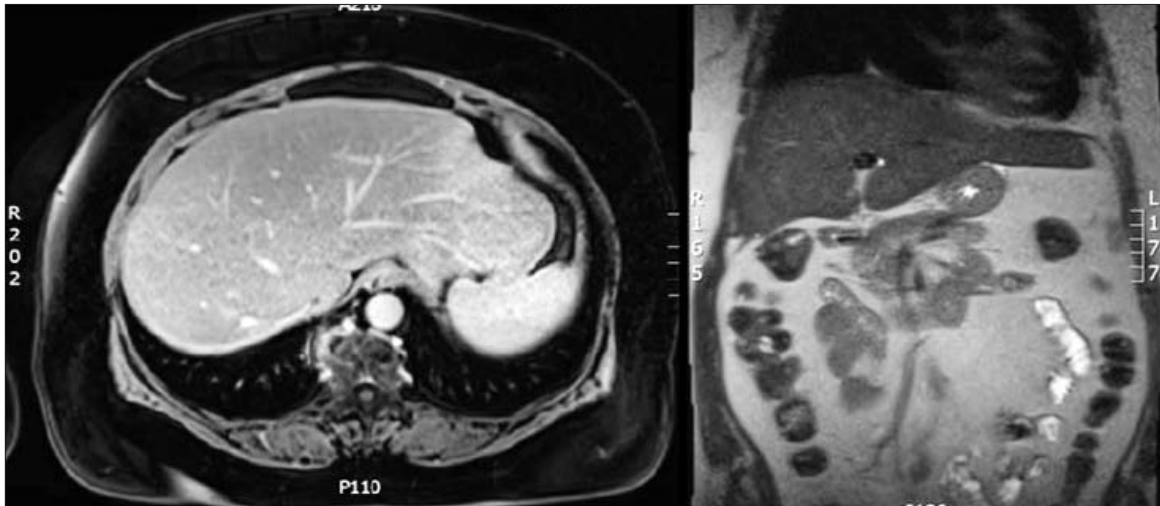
MRI images in the same patient one year after surgery showing no focal liver lesions with significant hypertrophy of liver remnant (left lobe)
